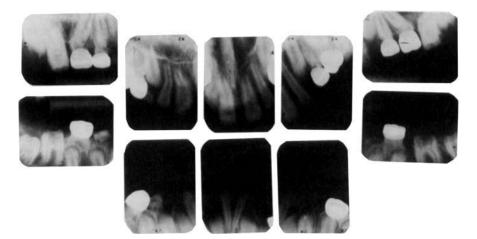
Radiographs of S.M. at 10 years show marked delay in eruption of permanent teeth. The only permanent teeth in occlusion are the maxillary incisors, the maxillary first molars and mandibular central incisors. Note the rough mottled appearance of the unerupted crowns of the mandibular first molars suggesting that they have been partially resorbed.
